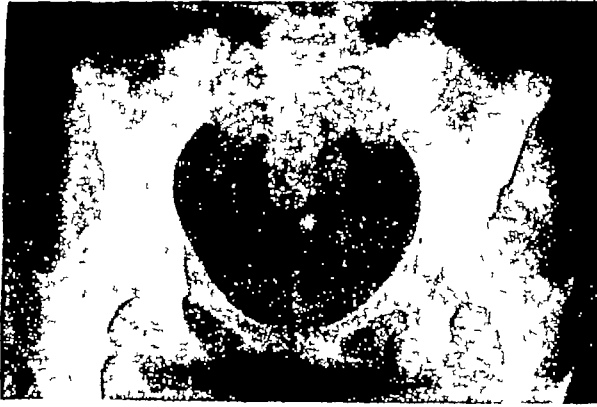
X-ray of patient shown in Fig 11A Simple upward subluxation with the femoral head riding approximately halfway out of the acetabulum
